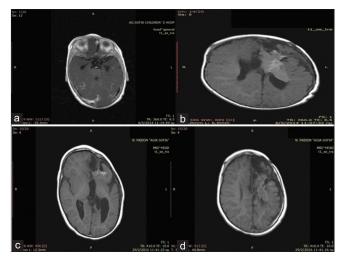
(a) Magnetic resonance imaging scans obtained at 8 months of age after two attempts to address the tumor surgically. The presence of deep-seated residual tumor is noted, as well as the appearance of cortical tubers. (b) Follow-up at 2-year postoperative does not show signs of recurrence.
